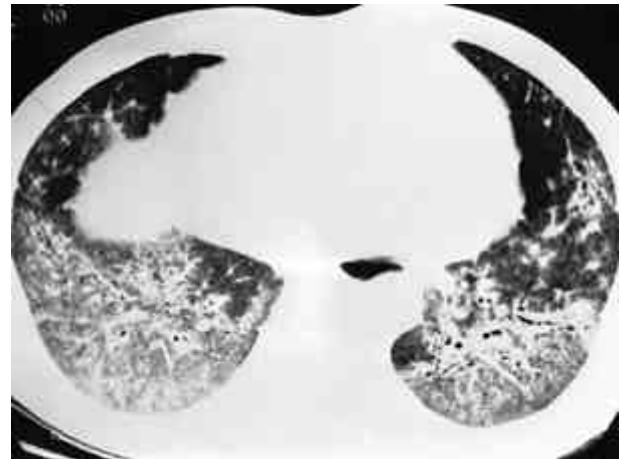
High-resolution CT of a 51-year-old man with progressive systemic sclerosis shows predominantly ground-glass opacity which is located mainly peripherally.
